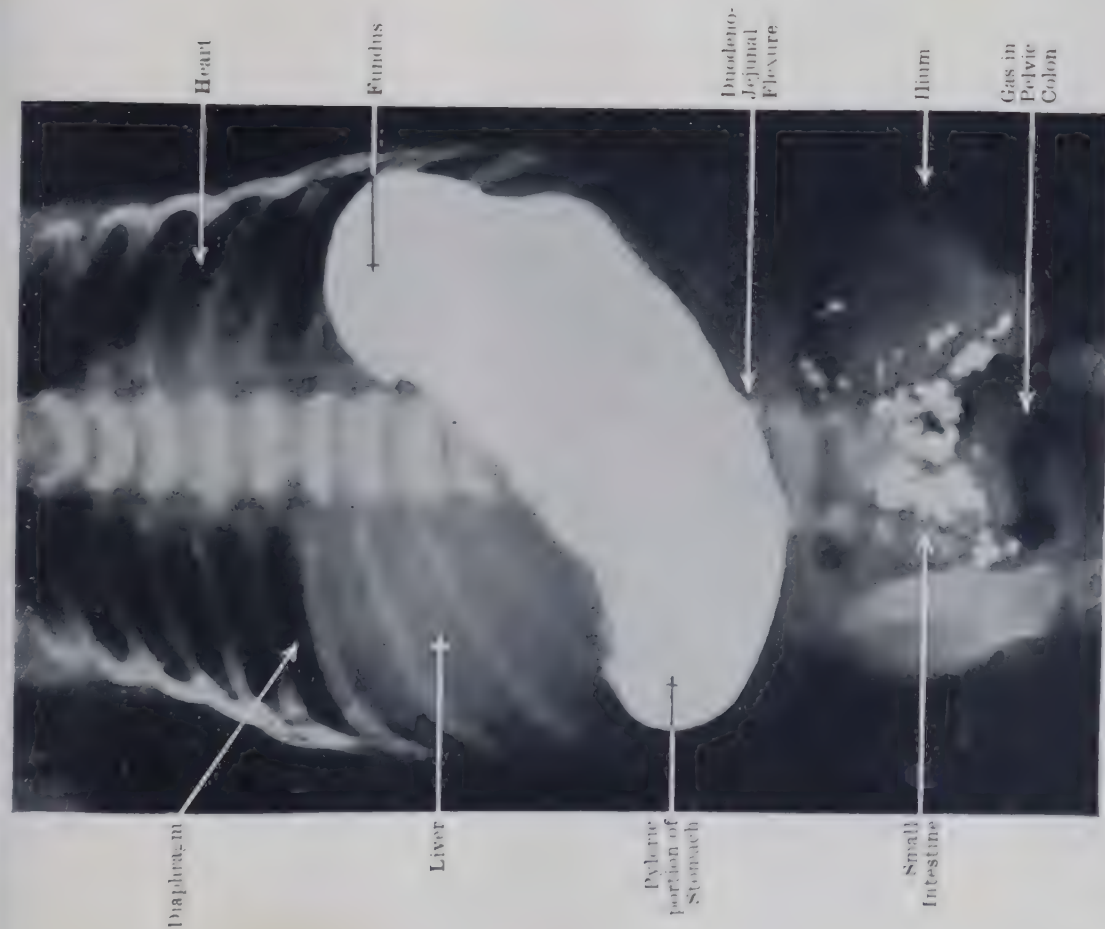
RADIOGRAPH OF STOMACH, FILLED WITH BARIUM, OF INFANT FIVE WEEKS OLD, SHOWING THE CHARACTERISTIC "STEER-HORN" FORM. (DR. G. G. ALLAN.) Compare with Fig. 2 and Plate LIV. Fig. 1, p. 613.
